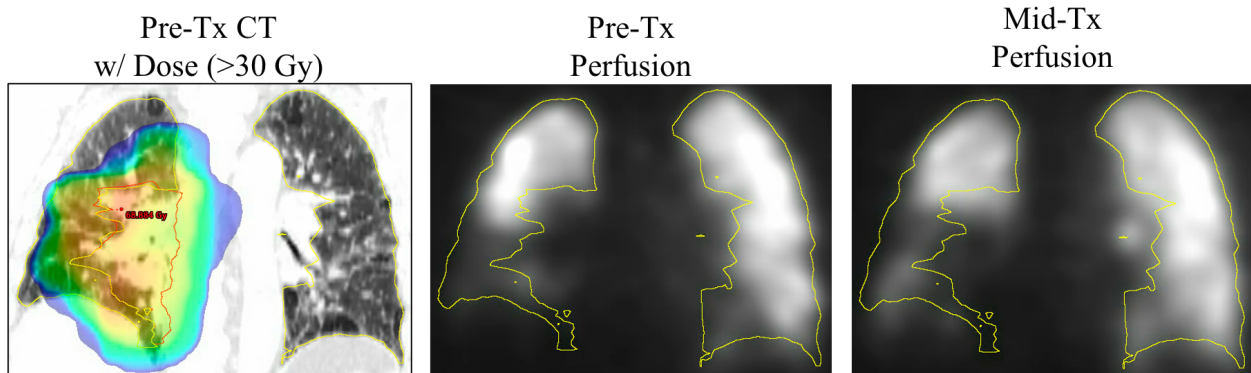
A qualitative example demonstrating the perfusion SPECT distribution prior to and during radiation treatment for example patient VA029. Planned dose >30 Gy is overlaid on the treatment planning CT scan.
